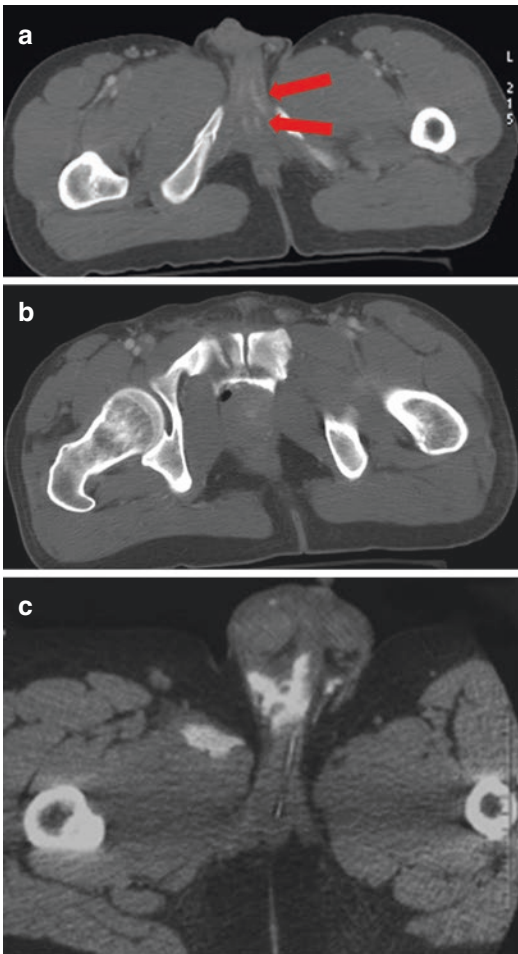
Unenhanced axial CT image (a), delayed axial CT cystographic image (b and c). A mural hematoma causes ischiocavernosus and bulbocavernosus muscle high attenuation (*short arrows*) (a). Extravasation of iodinated c.m. is associated in the periprostatic space (b) and along the bulbar tract of the urethra (c)
